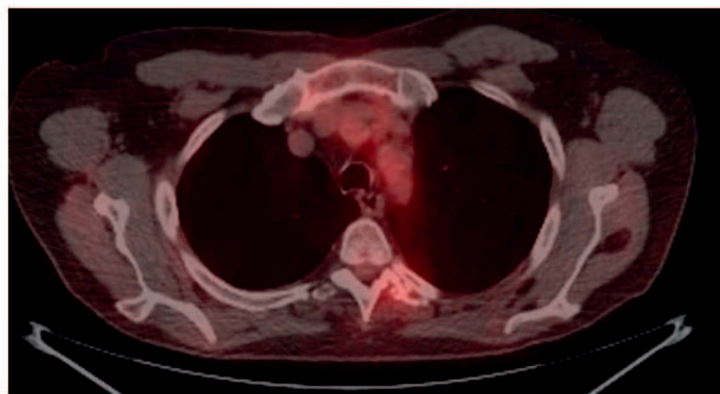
FDG PET imaging pre- and post-SBRT to the T4 squamous metastasis. FDG, fluorodeoxyglucose; PET, positron emission tomography; SBRT, stereotactic body radiotherapy.
